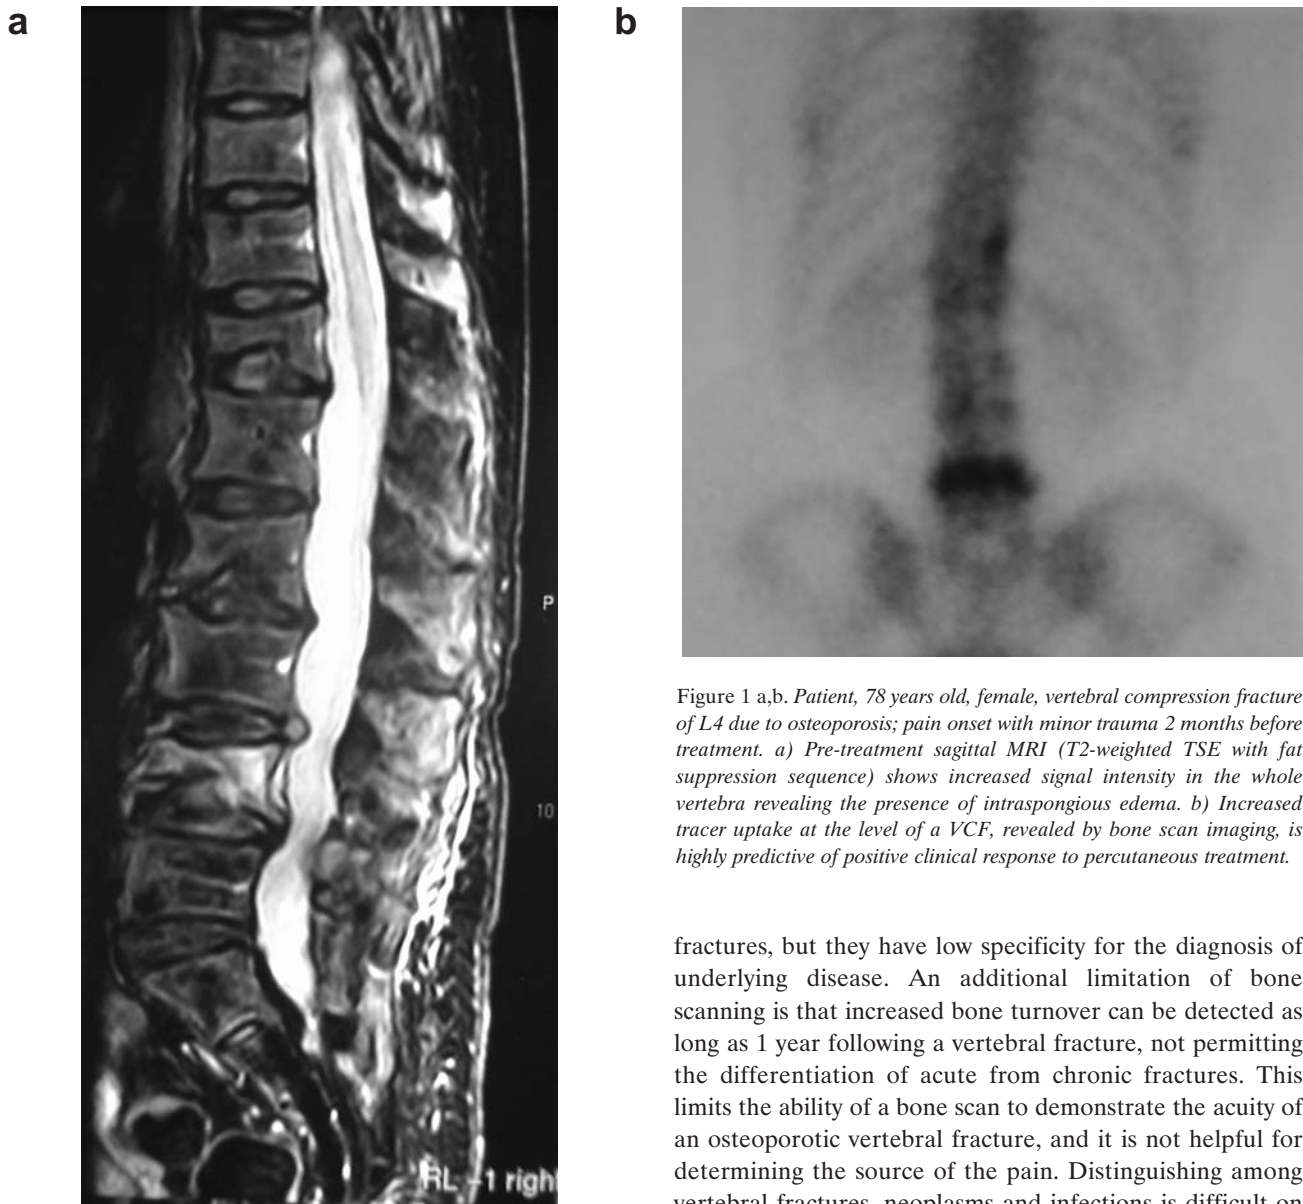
a,b. Patient, 78 years old, female, vertebral compression fracture of L4 due to osteoporosis; pain onset with minor trauma 2 months before treatment. a) Pre-treatment sagittal MRI (T2-weighted TSE with fat suppression sequence) shows increased signal intensity in the whole vertebra revealing the presence of intraspongious edema. b) Increased tracer uptake at the level of a VCF, revealed by bone scan imaging, is highly predictive of positive clinical response to percutaneous treatment.
